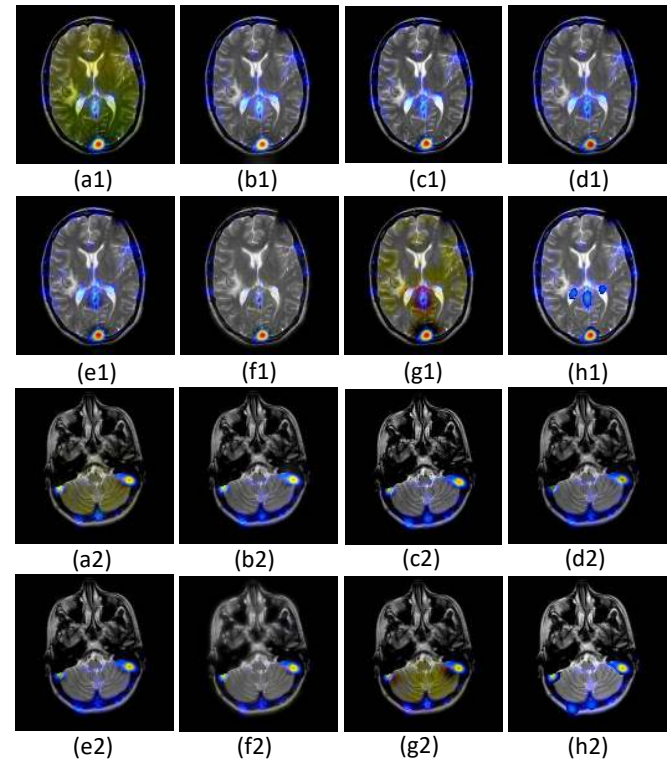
Two pairs of MRI-SPECT fusion results of eight different fusion methods.(a1),(a2) LP-SR method;(b1),(b2) CNN method (c1),(c2) CFL method;(d1),(d2) NSST-PAPCNN method;(e1),(e2)NSCT-PC-LLE; (f1),(f2) LRD; (G1),(G2) NSCT-SR; (h1),(h2) the proposed method.
